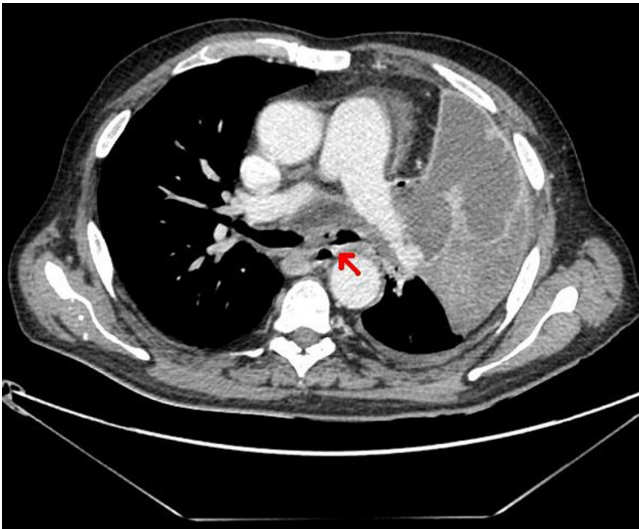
CT scan showing communication between the esophagus and the bronchus associated with a mediastinal mass.
